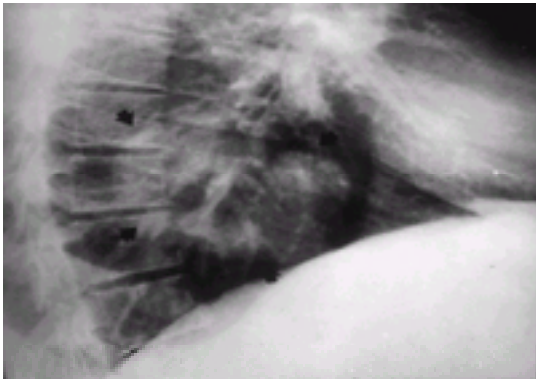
Chest radiograph, lateral view: this shows a lobulated mass behind the heart due to para-oesophageal varices.
